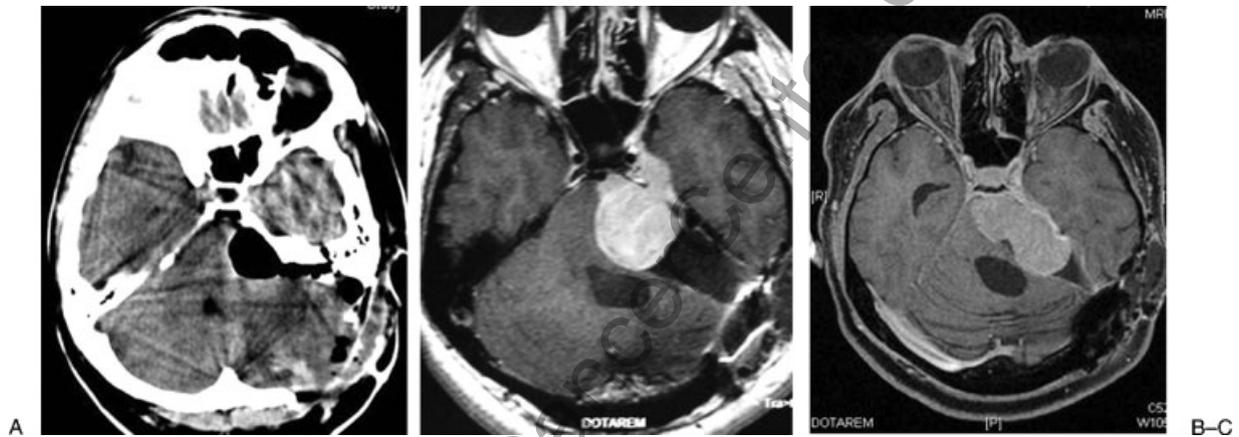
(A) Axial CT after radical re-resection was undertaken in May 2007. (B) Rapid and aggressive recurrence within 3 months of surgery, leading to another operative resection against symptomatic brainstem compression. (C) Yet again aggressive regrowth of the residual tumor within a month of the last operation with significant brainstem compression that proved to be fatal.
